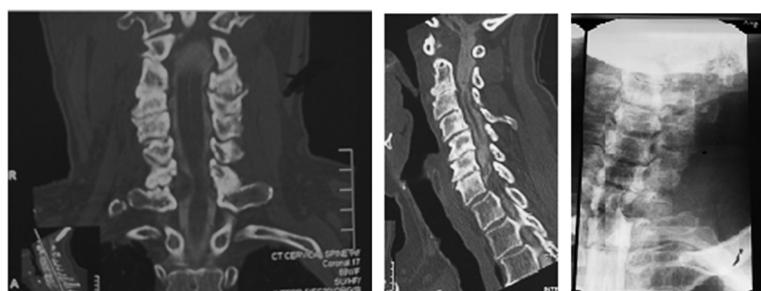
Myelogram and post-myelogram CT.
